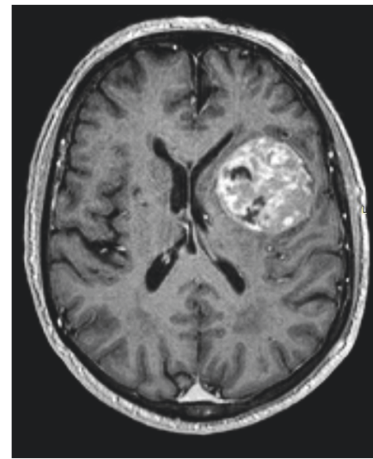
Axial T1-weighted postcontrast MR images of a patient with HGG used for RTP.
